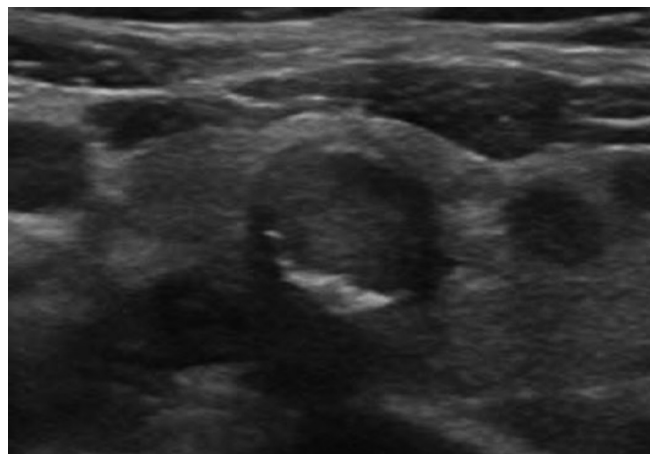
A 48-year-old woman with a papillary thyroid carcinoma and negative for the BRAF V600E mutation. The thyroid nodule with peripheral rim calcification does not have any ultrasonographic features suggesting malignancy (unlike Fig. 2 and Fig. 3) and it was regarded as a benign nodule on preoperative ultrasonography.
